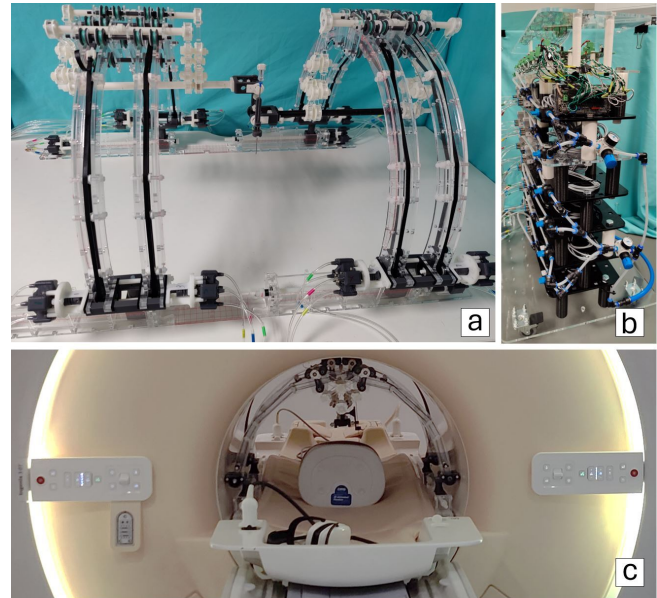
Proposed needle insertion robot on a table (a), the tower control platform (b) and (c) the robot within MRI scanner
